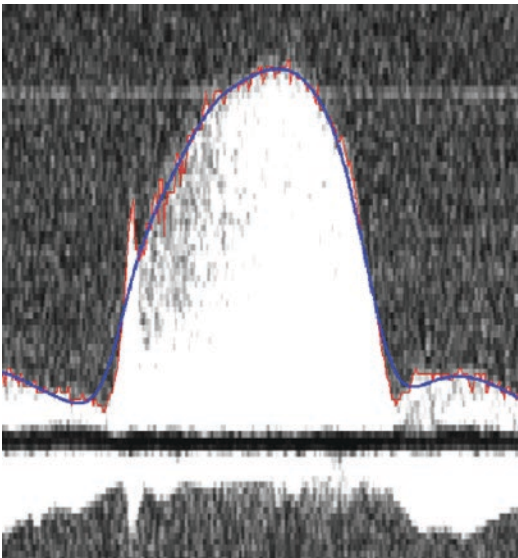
Automatic trace of Doppler US image of TR jet. Red raw trace, Blue smoothed trace
